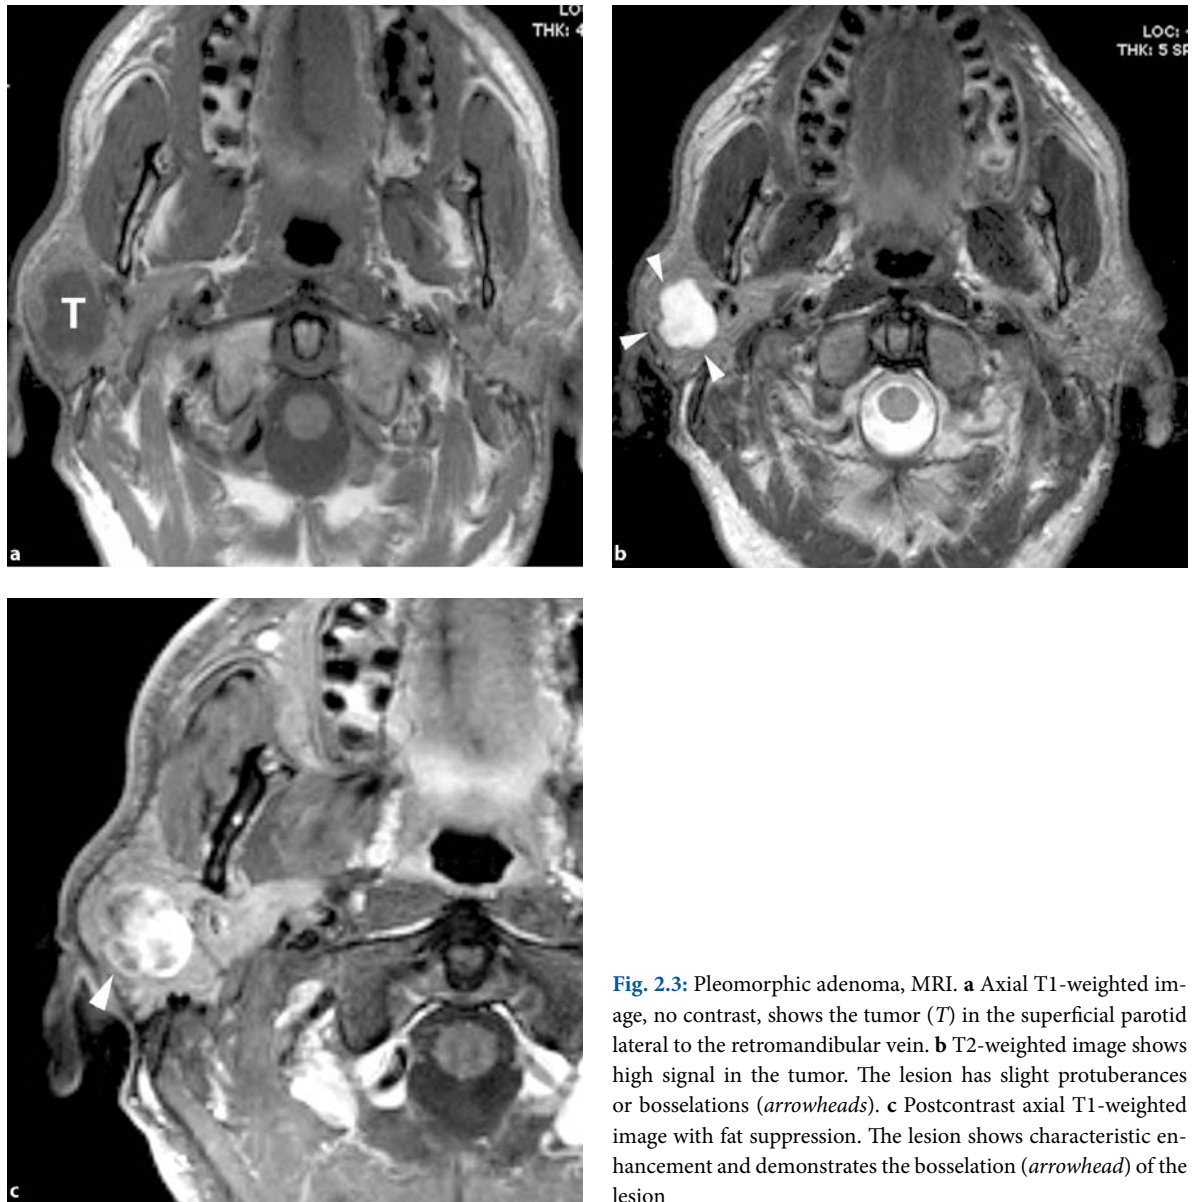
Pleomorphic adenoma, MRI. a Axial T1-weighted image, no contrast, shows the tumor (*T*) in the superficial parotid lateral to the retromandibular vein. b T2-weighted image shows high signal in the tumor. The lesion has slight protuberances or bosselations (*arrowheads*). c Postcontrast axial T1-weighted image with fat suppression. The lesion shows characteristic enhancement and demonstrates the bosselation (*arrowhead*) of the lesion
